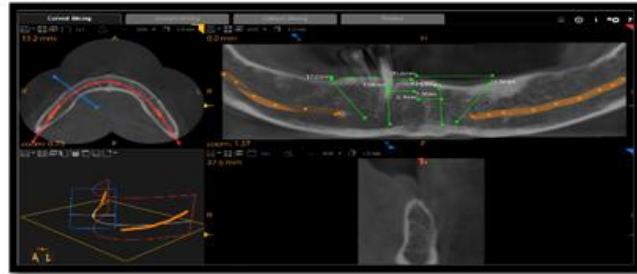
CBCT planning for mandibular implants
